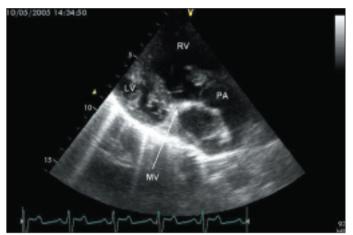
Parasternal long-axis view showing the atretic mitral valve, hypoplastic left ventricle and the posteriorly located pulmonary artery
